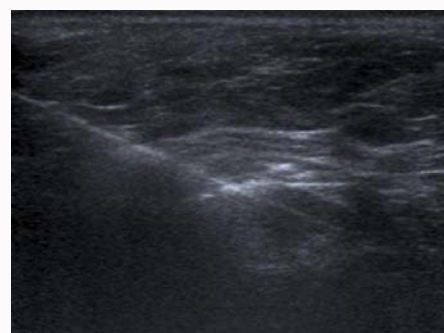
Transpectoral US of the area of interest. Using the modified ultrasound technique the abnormal lymph node is now closer to the transducer and there is no anatomical limitation of the shoulder, underlying vessels or overlying breast cancer.
